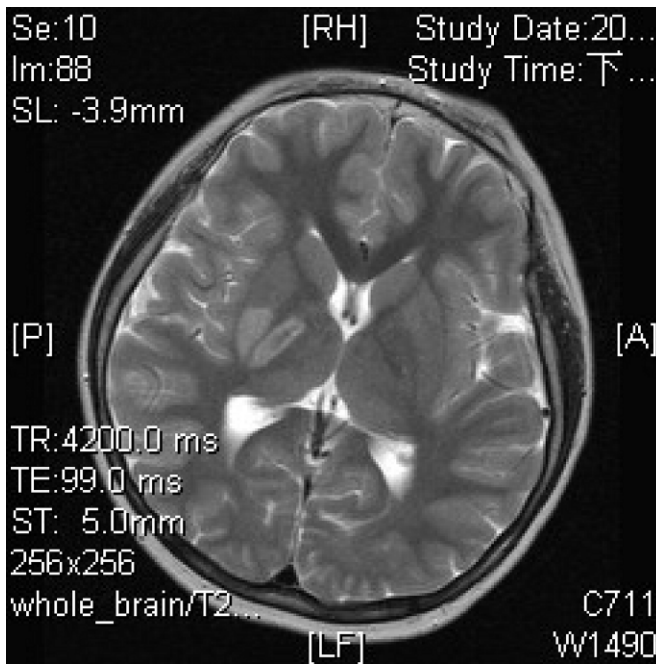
Hyperintensity on magnetic resonance T2-weighted imaging at the right hippocampus, posterior caudate nucleus, posterior corona radiata, posterior putamen, and anterolateral thalamus.
